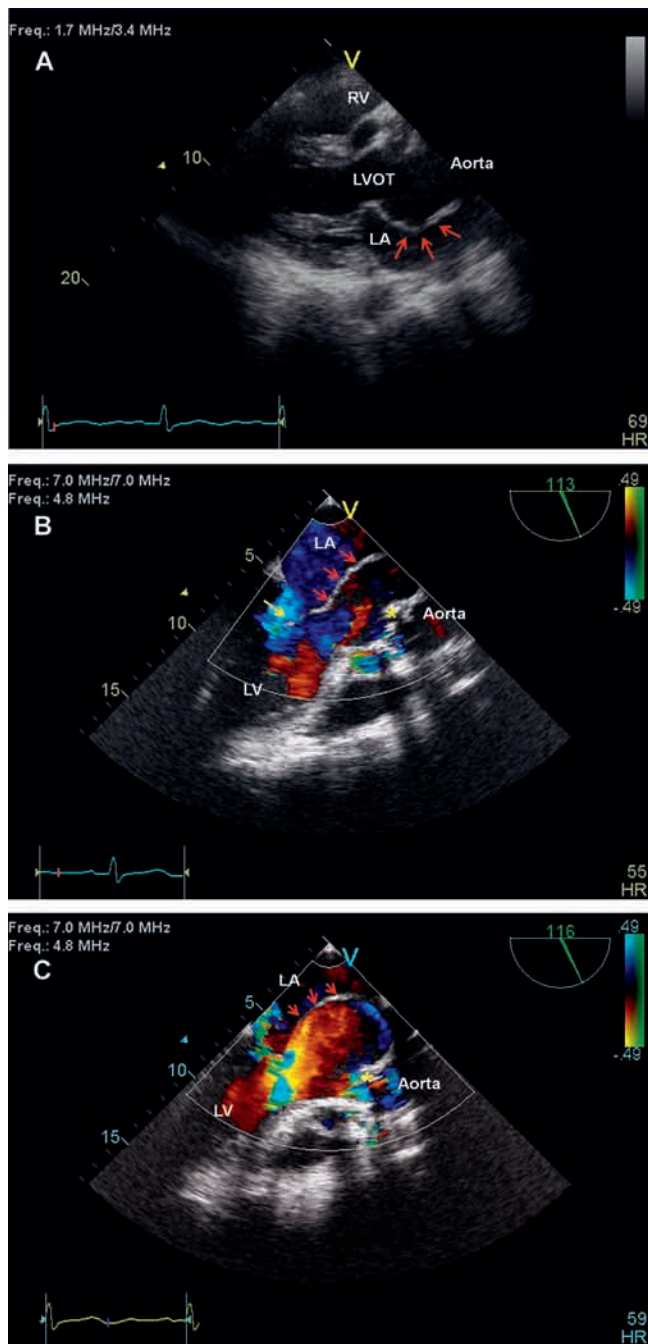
Panel A. 2D Echocardiogram. Parasternal long axis view showing aneurysmal left ventricular outflow tract (arrows). Panel B. TEE showing gross displacement of bio-prosthetic aortic valve (asterisk) with aneurysmal dilatation pressing into the left atrium (arrow: mitral valve). Panel C. Aneurysm expanded with left ventricular contraction; aortic valve (asterisk). RV = right ventricle; LA = left atrium; LV = left ventricle; LVOT = left ventricular outflow tract.
